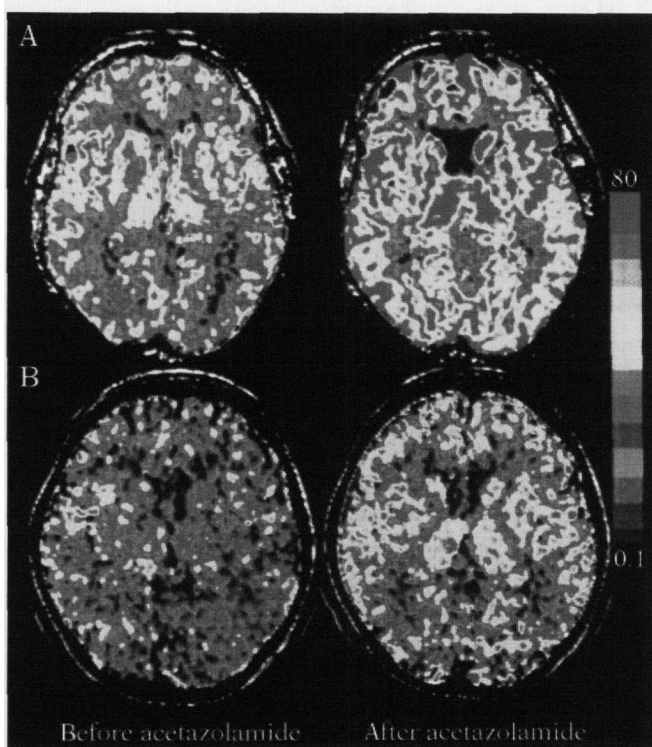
Actual records of xenon CT. A) Cerebral blood flows in a patient with lacunar infarction with transient signs. B) Cerebral blood flows in a patient with lacunar infarction with long-lasting signs. Both patients had lacunar infarction in the left hemisphere. The cerebral blood flows in the cerebral cortex and cerebral white matter contralateral to the lacunar infarction were lower in B than in A. After the intravenous injection of acetazolamide, the cerebral blood flows were increased. The cerebrovascular acetazolamide reactivity was lower in B than in A.
